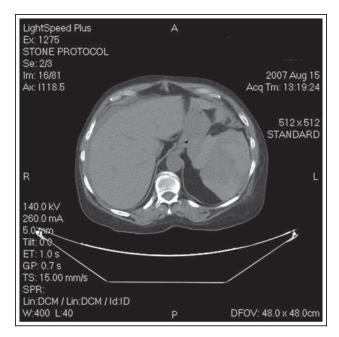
Axial computed tomography of the abdomen demonstrating the shattered spleen post-SWL with associated hematoma and free fluid.
